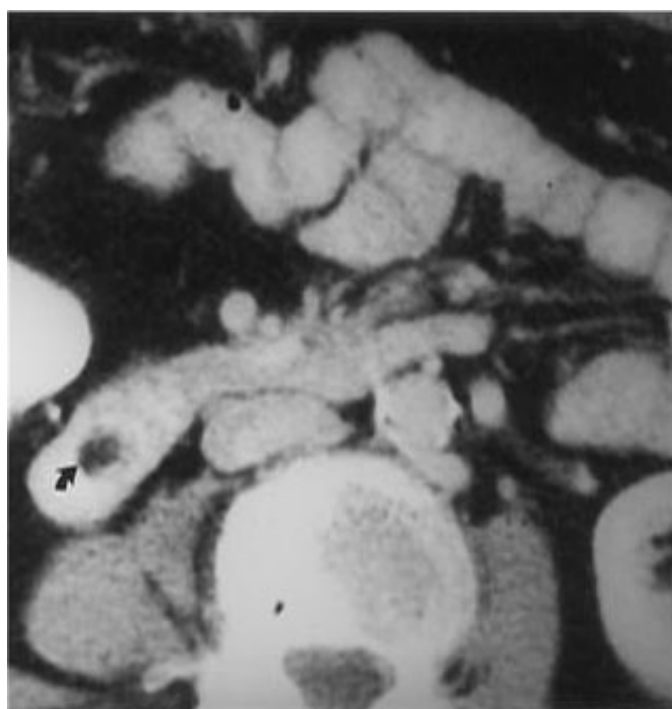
Computed tomography scan of the abdomen showing an intraluminal defect in D2–D3 with no obstruction.
